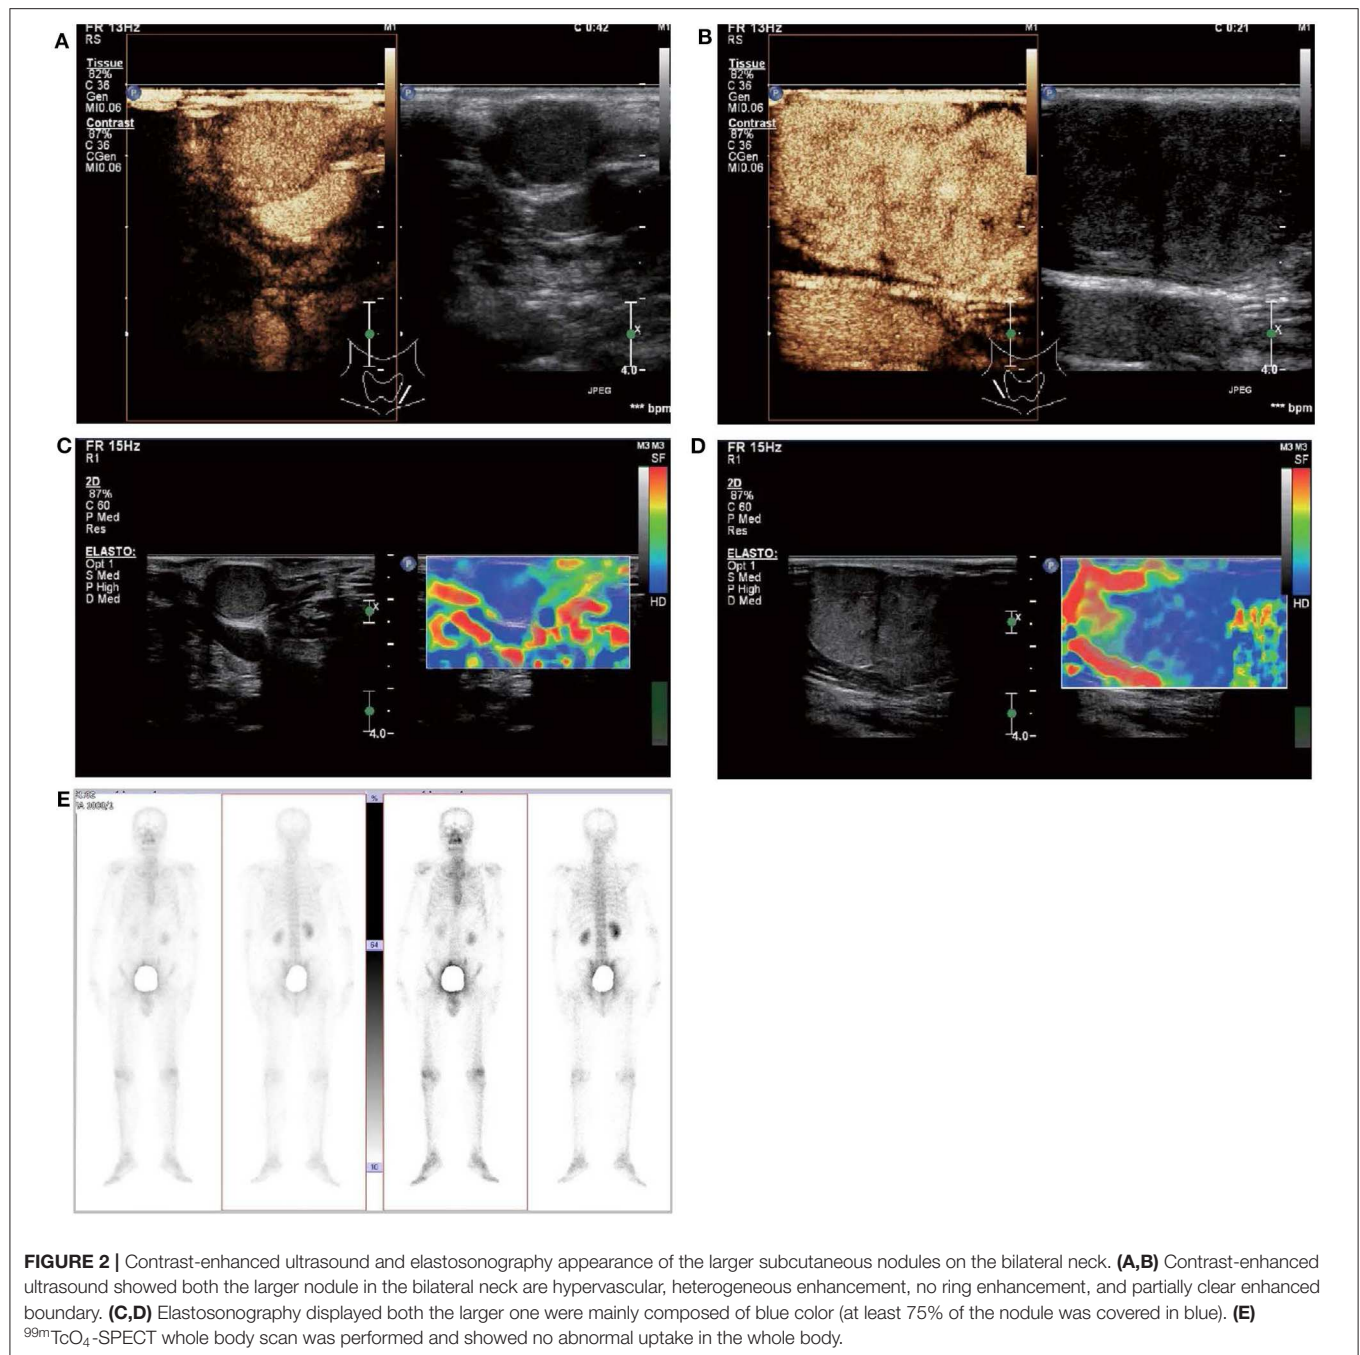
Contrast-enhanced ultrasound and elastosonography appearance of the larger subcutaneous nodules on the bilateral neck. (A,B) Contrast-enhanced ultrasound showed both the larger nodule in the bilateral neck are hypervascular, heterogeneous enhancement, no ring enhancement, and partially clear enhanced boundary. (C,D) Elastosonography displayed both the larger one were mainly composed of blue color (at least 75% of the nodule was covered in blue). (E) $^{99m}\text{TcO}_4$ -SPECT whole body scan was performed and showed no abnormal uptake in the whole body.
